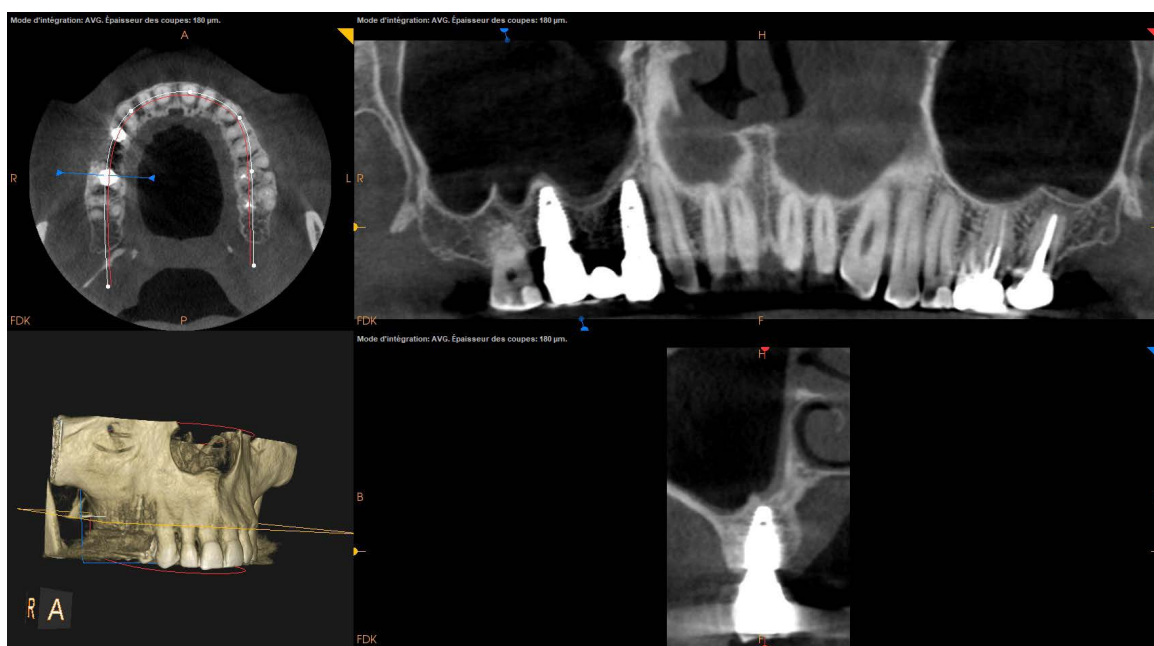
a-b): CBCT of the patient after implant insertion.
